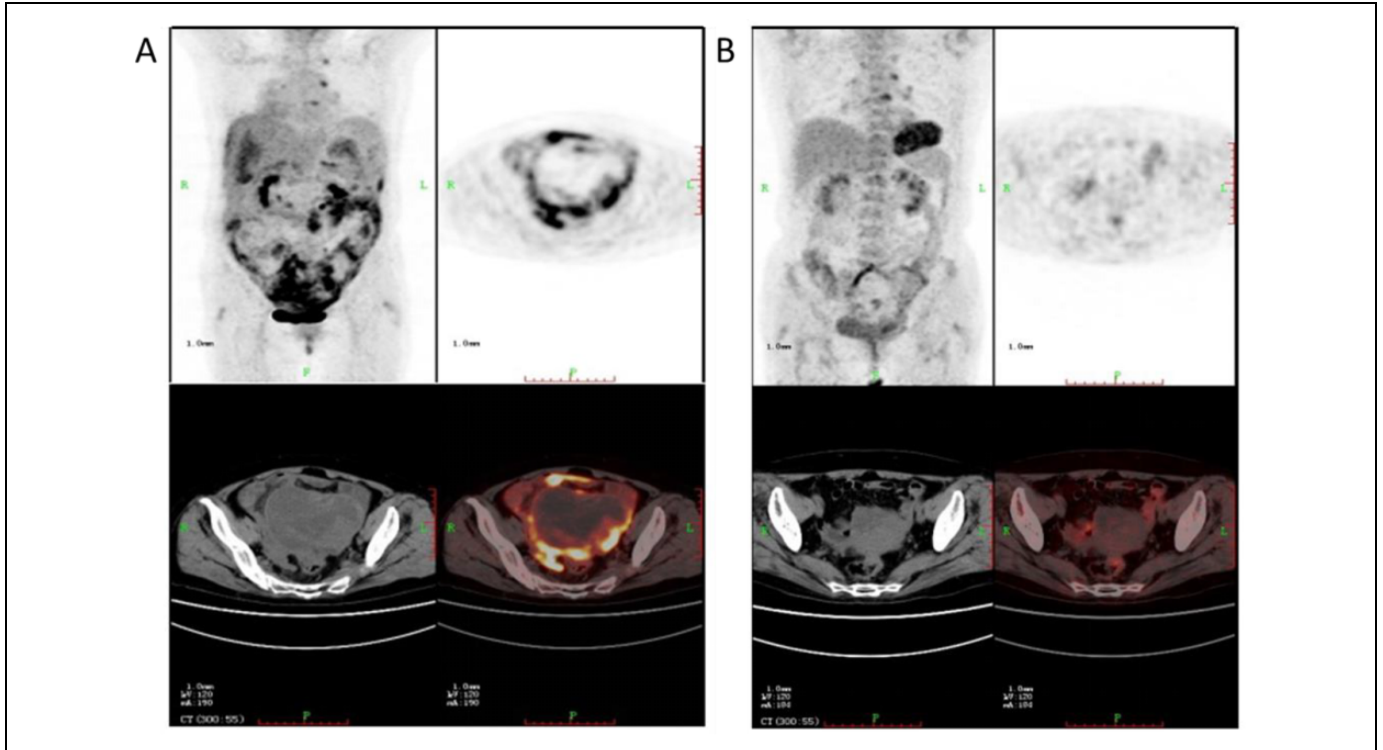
PET-CT scans of a 71-year-old female (A) prior to treatment, and following the treatment (B). The results revealed that the metabolism of the lesions was significantly decreased.
